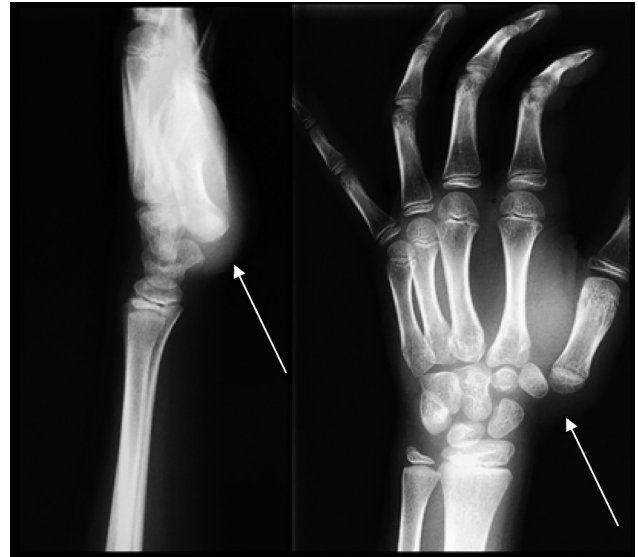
Lateral and AP radiographs showing the first TMC joint dislocation (arrows).
